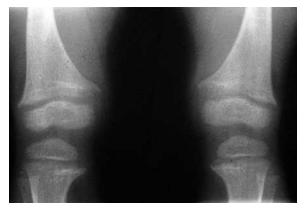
Hypophosphatemic rickets. Radiograph of the knees of a 2-year-old girl with bowlegs. Note the widened space between the metaphyses and epiphyseal ossification center, cupping and splaying of the metaphyses of the femur and tibia, and an overall decreased density of bone. (*Courtesy M. Goodman, MD, Children's Hospital of Pittsburgh, Pittsburgh, Pa.*)
